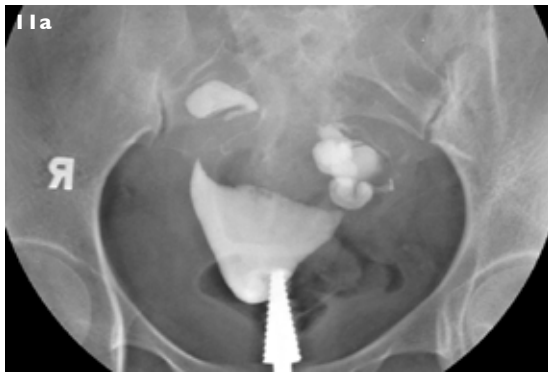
Bilateral hydrosalpinges. (a) Hysterosalpingogram shows tubular convoluted structures on both sides of the uterus, representing bilateral hydrosalpinges. No intra-peritoneal spillage of contrast is demonstrated. (b) Corresponding ultrasonography image shows the right hydrosalpinx as a tubular cystic structure in the right adnexa containing internal echoes.
